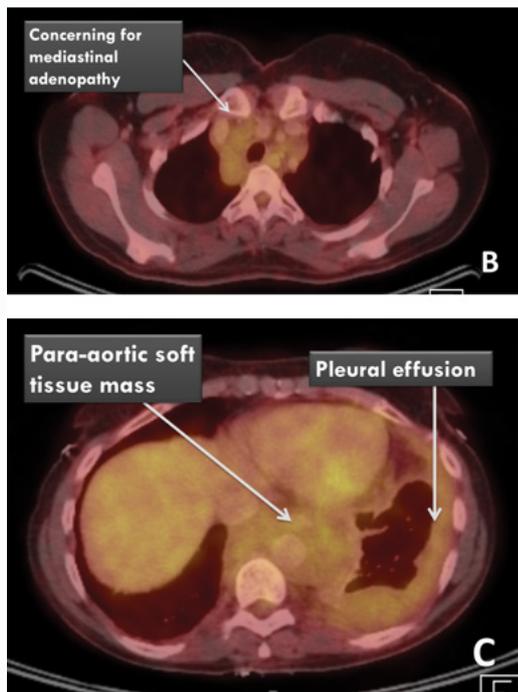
Fused axial Positron-Emission Tomography (PET) and Computerized Tomography (CT) images demonstrating diffuse increased Fluoro-Deoxyglucose (FDG) uptake throughout the mediastinum, corresponding to a large confluent soft tissue mass, interpreted as extensive mediastinal lymphadenopathy, particularly in the right anterior mediastinum, with maximum standardized uptake value (maxSUV) of 3.2 (upper panel), and in the posterior mediastinum around the descending aorta, with maxSUV of 3.4, as well as a moderate-sized loculated left-sided pleural effusion, with diffuse increased FDG uptake and maxSUV of 2.7 (lower panel).
